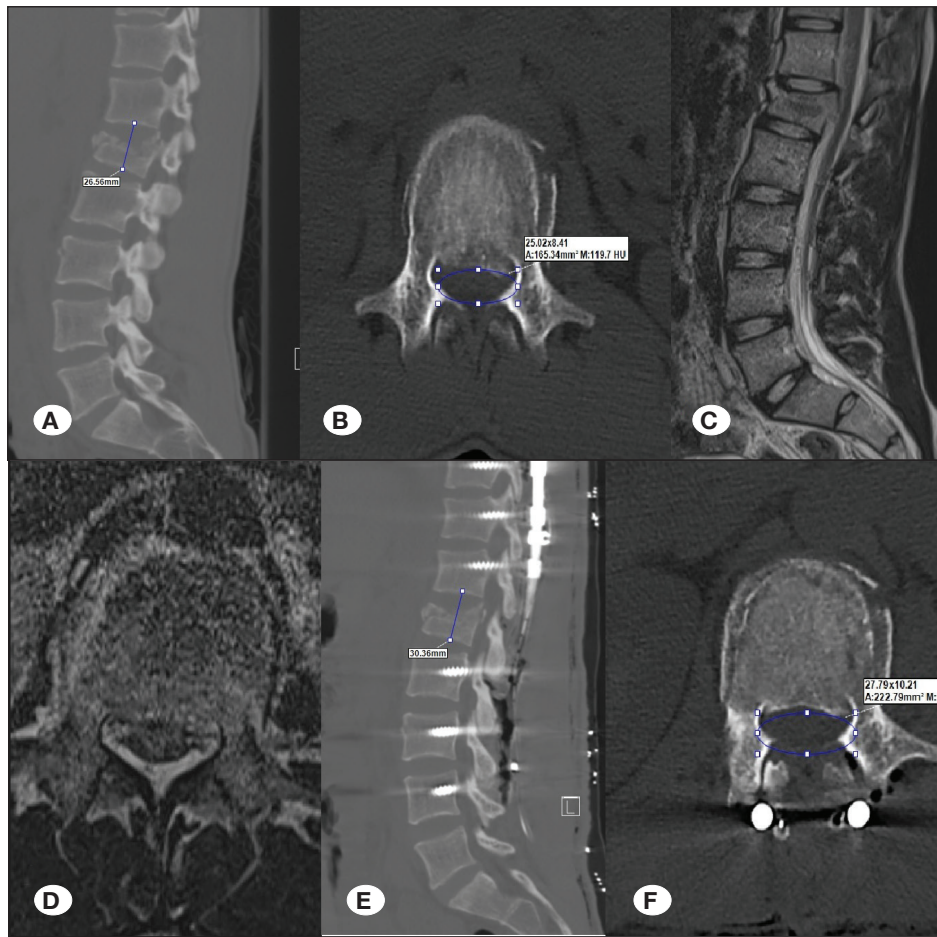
Distraction and ligamentotaxis in posterior instrumentation of L1 burst fracture. Preoperative sagittal (A) and axial (B) computed tomography (CT) scans, and T2W sagittal (C) and axial (D) magnetic resonance images showing spinal cord compression with the measurements. Postoperative sagittal (E) and axial (F) CT images showing the increase in the corpus height and decrease of the percentage of spinal cord compression at L1 fracture level. The fractured vertebral unit height increased from 26.56 mm to 30.36 mm (+3.80 mm) (A,E), and spinal cord compression from 40% to 23% (+17%) (B,F).
